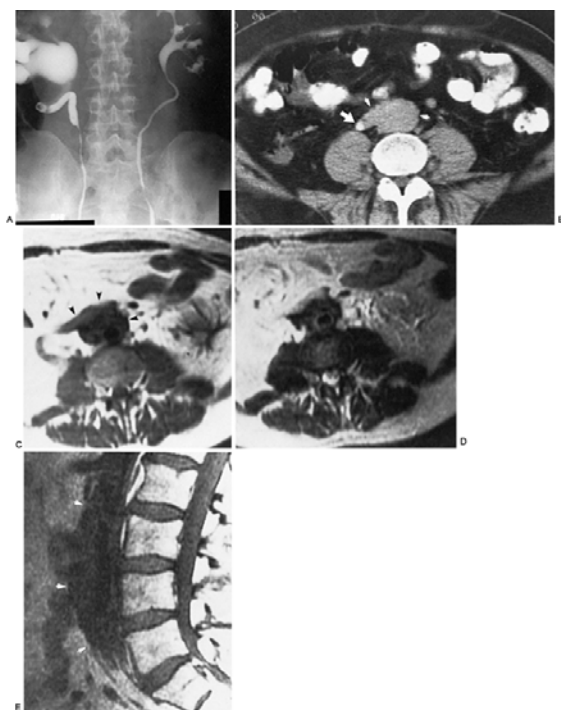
Benign idiopathic retroperitoneal fibrosis. A: Retrograde pyelography demonstrates medial displacement of both ureters at the level of L-5. The right midureter is narrowed, and there is associated right hydronephrosis. B: Computed tomography (CT) scan demonstrates plaque-like deposition of fibrous tissue surrounding and obscuring both the aorta and inferior vena cava (*arrowheads*). The right ureter is entrapped by an extension of the fibrous process to the right of the midline (*arrow*). C: T₁-weighted magnetic resonance imaging (MRI) scan at 1.5 T demonstrates that the plaque (*arrowheads*) is of low signal intensity consistent with fibrous tissue. Note how the fibrous tissue encompasses both the aorta and inferior vena cava, rendering them almost indistinguishable. Note also the extension of the fibrous plaque to the right as demonstrated in the previous CT scan. D: T₂-weighted axial image demonstrates no change in the signal intensity of the retroperitoneal plaque, indicating that it is comprised entirely of fibrous tissue, confirming the diagnosis of benign retroperitoneal fibrosis. The wall of the aorta has increased slightly in intensity, making it now visible. E: T₁-weighted sagittal MRI demonstrates the plaque in profile (*arrowheads*). The lesion is extensive and extends from L-1 to L-5.
